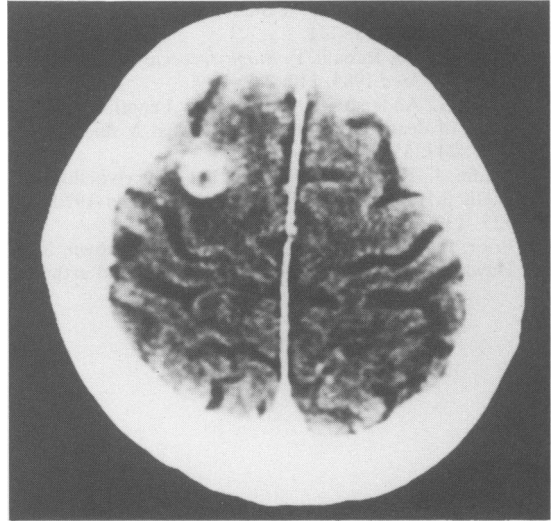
Brain CT scan showing a lesion compatible with a cerebral abscess in the left posterior frontal region (Case 3).
